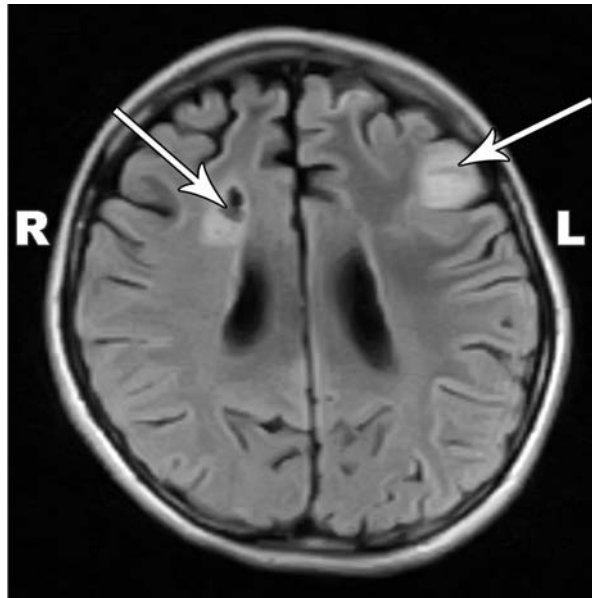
Magnetic resonance imaging (flair image) showing left frontal focal area of acute ischemic infarction (left arrow), and right parietal periventricular white matter old infarction (right arrow).
